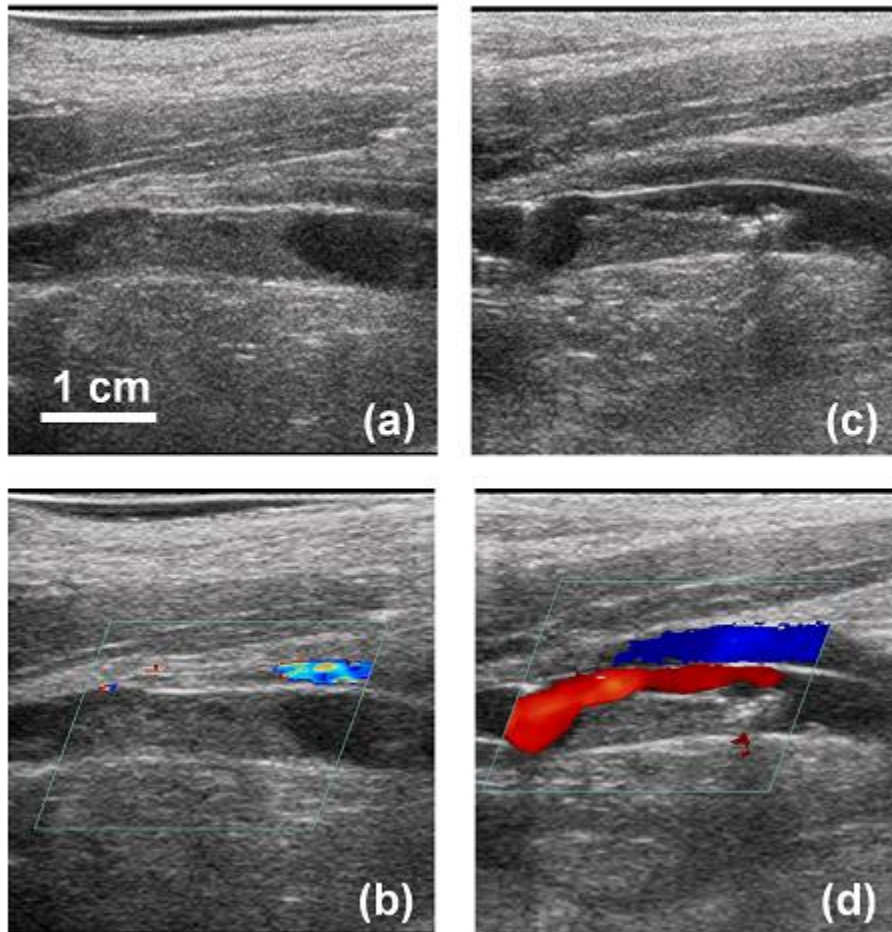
Example ultrasound images captured with a 10 MHz linear array probe of fully occlusive thrombus in 2D (a) and color Doppler (b). 2D and color Doppler images of a partially occlusive thrombus are shown in (c) and (d).
